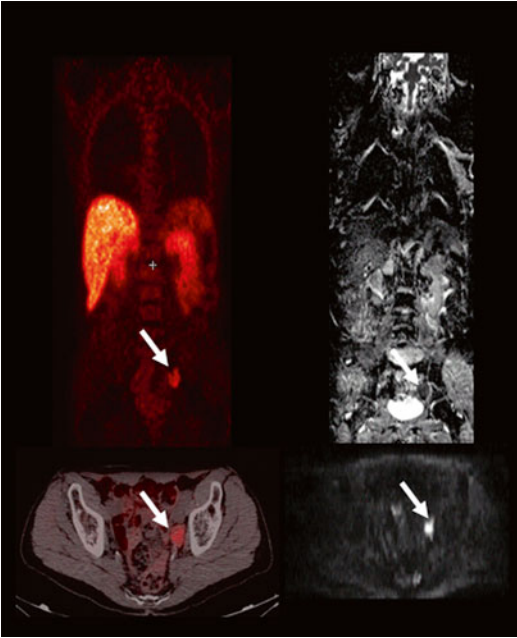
A 78-year-old male with prostate cancer presents with rising PSA. FDG PET-CT (*left*) and WB-DWI (*right*) show left pelvic metastatic node (*arrow*) with avid FDG uptake (*left*) and corresponding restricted diffusion on ADC map in coronal plane and axial DWI $b=800$ (*right*). Courtesy of Michael A. Jacobs, Ph.D. (JHU)
